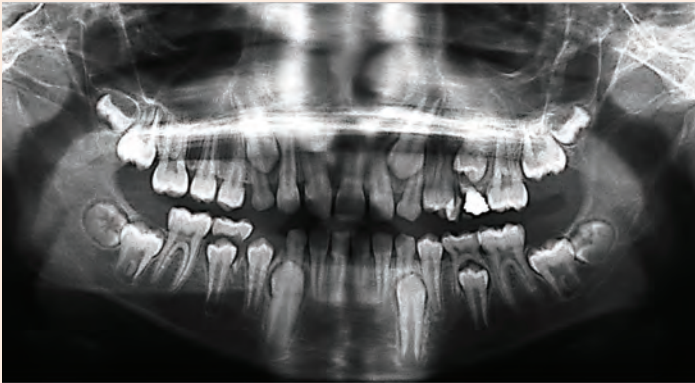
Panoramic radiograph of child in mixed dentition with no pathology or abnormality noted.
